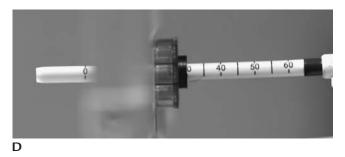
(A) Components in tray for one of the systems available for MRI-guided biopsy. (B) White introducer has measurement markings on surface. Black plastic ring (*arrow*) is moved to the marker for the calculated depth of the lesion (at 29 in this example). The trocar is passed through the white introducer to the hub. With this system, no skin nick is needed. The introducer and trocar are advanced through the hole in the square needle guide that is closest to the lesion, into the skin and the breast to the estimated depth for the lesion. (C) The trocar is replaced by the black insert and the patient is scanned to establish if the system is correctly positioned at the lesion. (D) If the system is at the lesion, the black insert is removed and the sampling, vacuum assisted needle is passed through the introducer. The needle can be rotated at small increments circumferential (360 degrees) or, depending on the relationship of the needle to the lesion, preferentially in a 180-degree radius.
